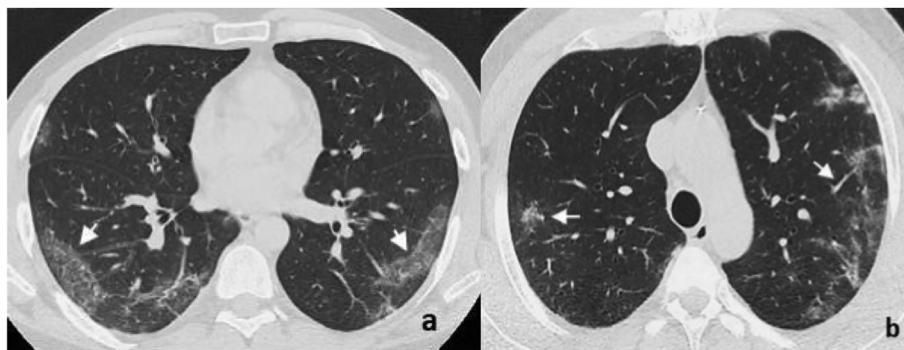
a. HRCT in a COVID-19 pneumonia patient shows bilateral patchy multilobar GGOs with peripheral posterior distribution, mainly in the lower lobes (arrows). b. A 58-year-old man with fever (38.3 °C), cough, dyspnea and laboratory-confirmed COVID-19 pneumonia; HRCT shows bilateral involvement with peripheral rounded GG opacities and vascular enlargement in GGO lesions (arrows).
